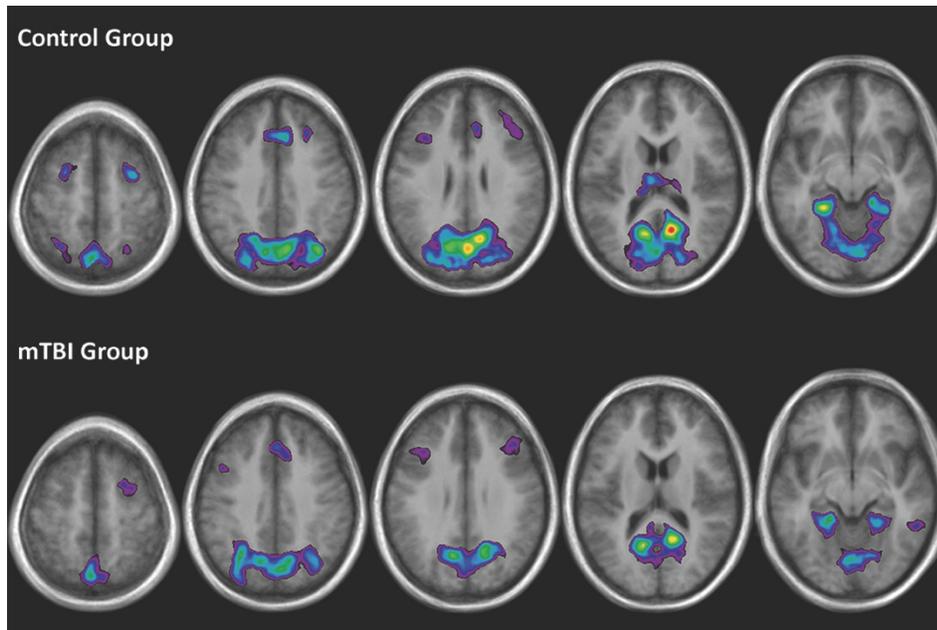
Functional MRI t-maps of controls and mTBI subjects during navigational memory task.
